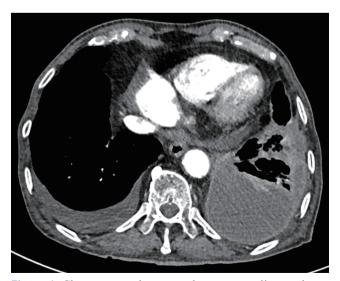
Chest computed tomography scan revealing moderate amount of pleural effusion in left hemithorax.
